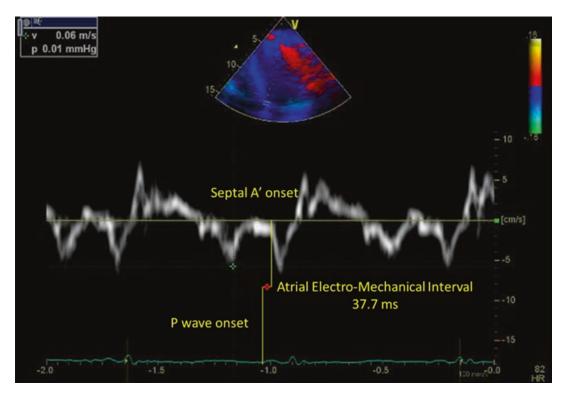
Tissue Doppler wave form with the red horizontal line between the two yellow vertical lines delineating the AEMI
